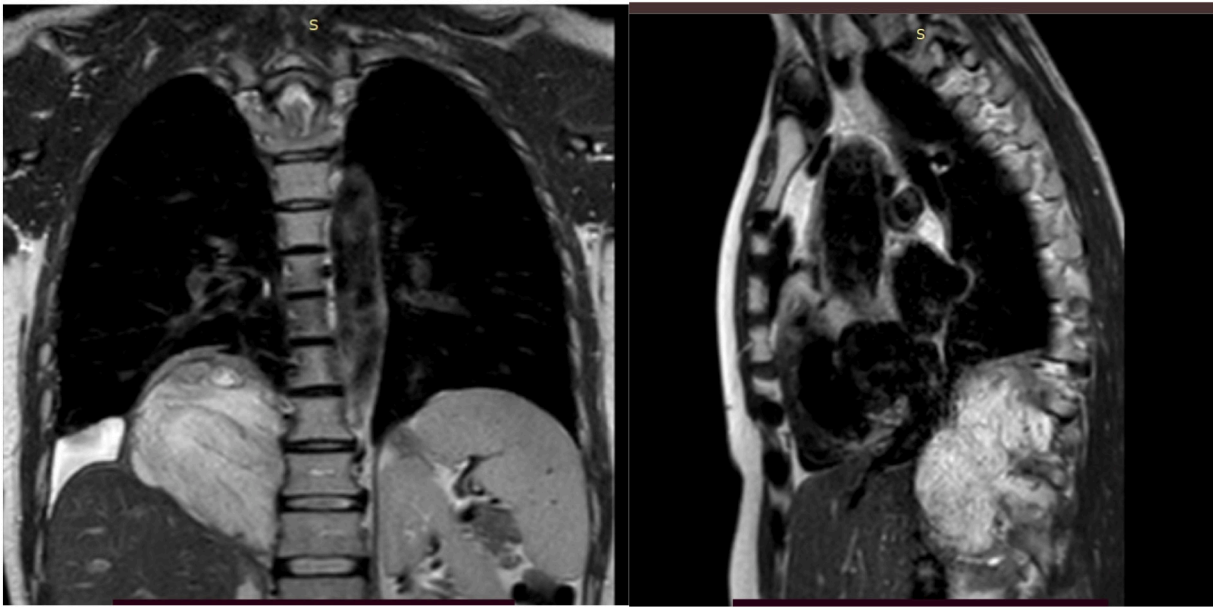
MRI showing a mass in the posterior mediastinum with right foraminal extension.
